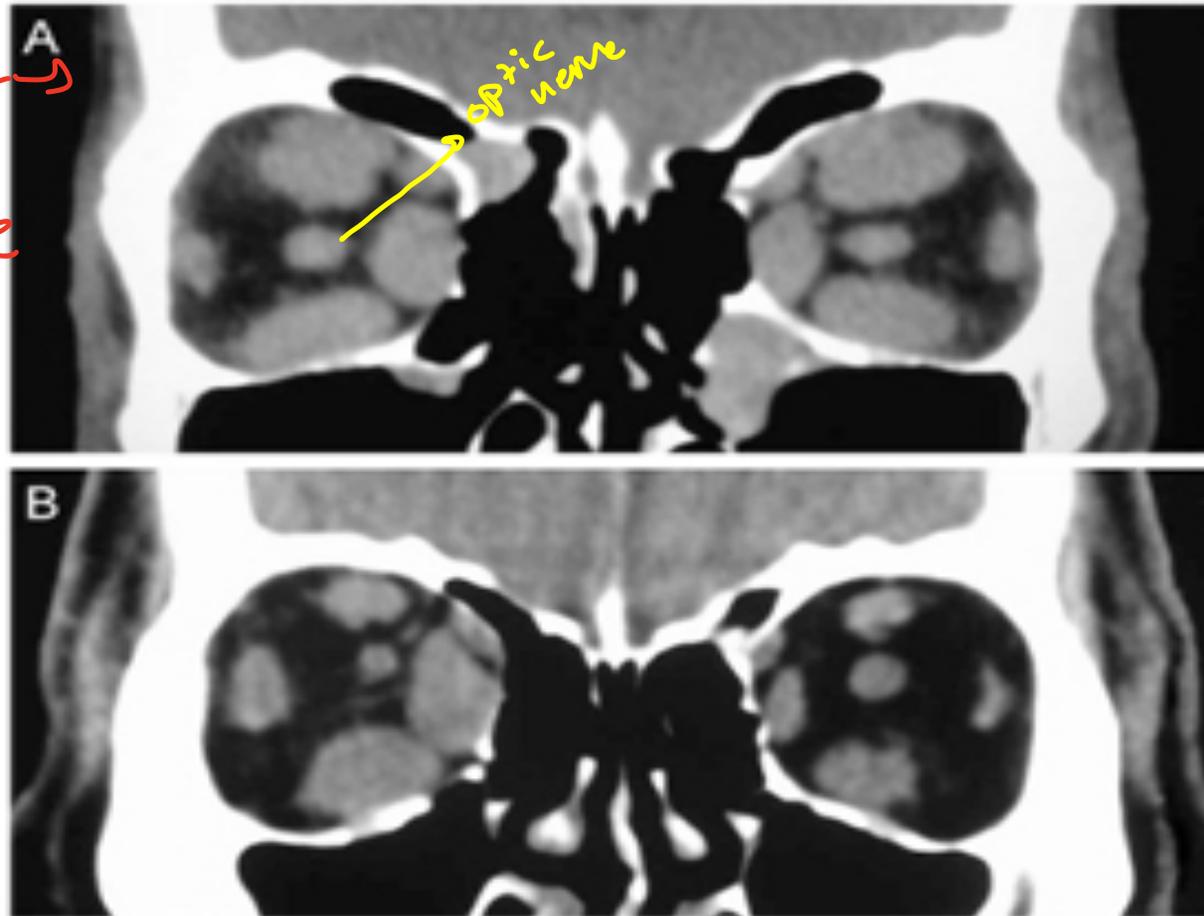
Coronal CT scans from two patients with Graves' orbitopathy. A) Patient with symmetric enlargement of the extraocular muscles in both orbits. B) Patient with asymmetric involvement of the extraocular muscles.
